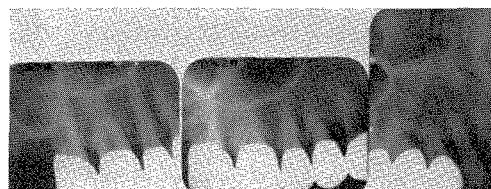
Roentgenograms of the completed work.
